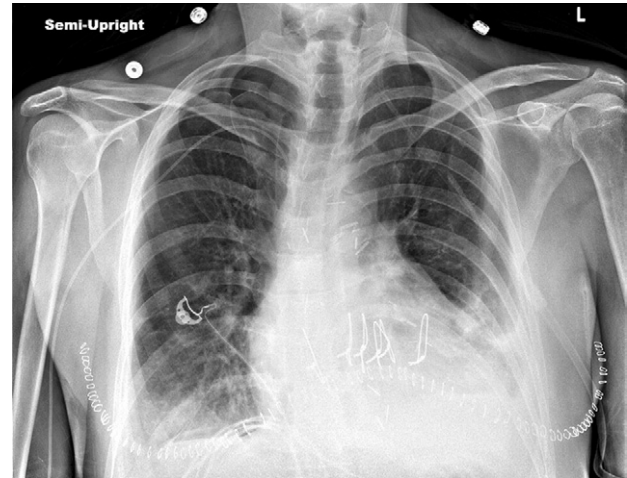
Postoperative chest radiograph.
